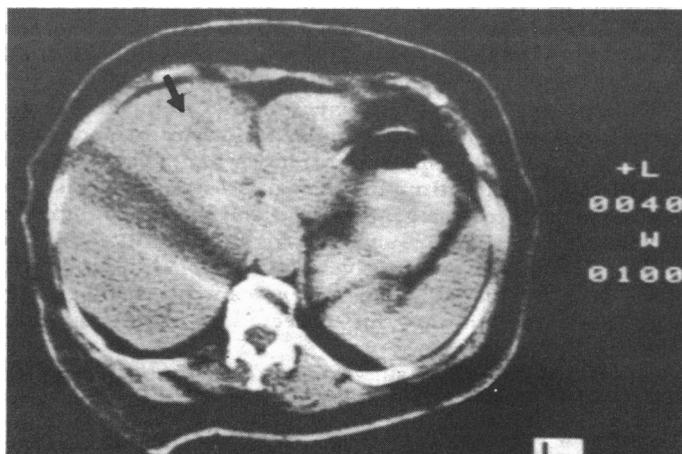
Example of occult hepatic metastases on computed tomography scan (arrowed).
